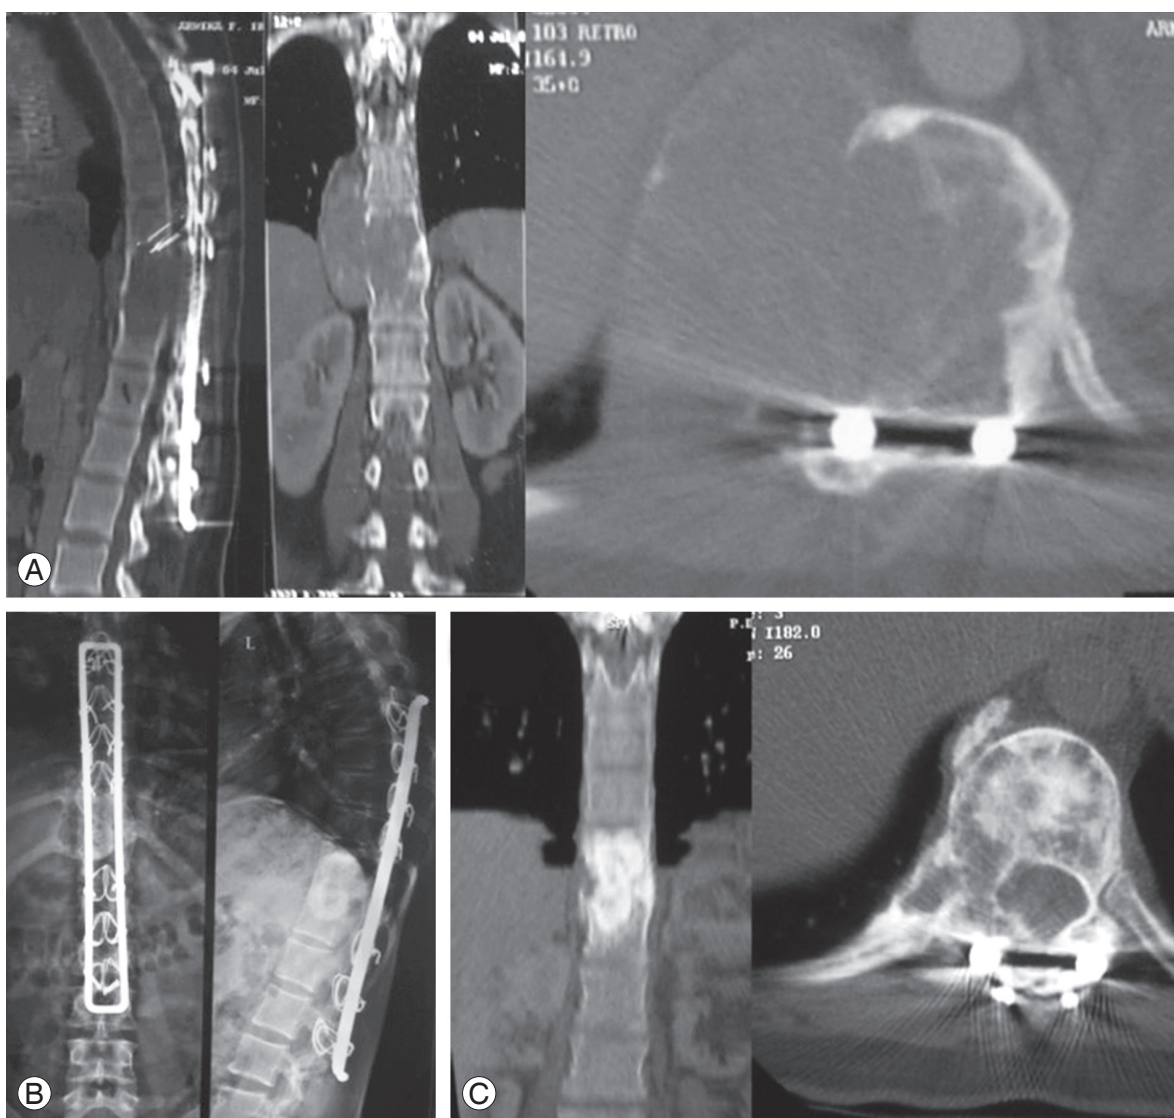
Case 2 with single recurrence. (A) Computed tomography (CT) image showing recurrence with well placed previous implants. (B) Radiograph at 10 years showing no recurrence. (C) CT image at 10 years showing no recurrence.
